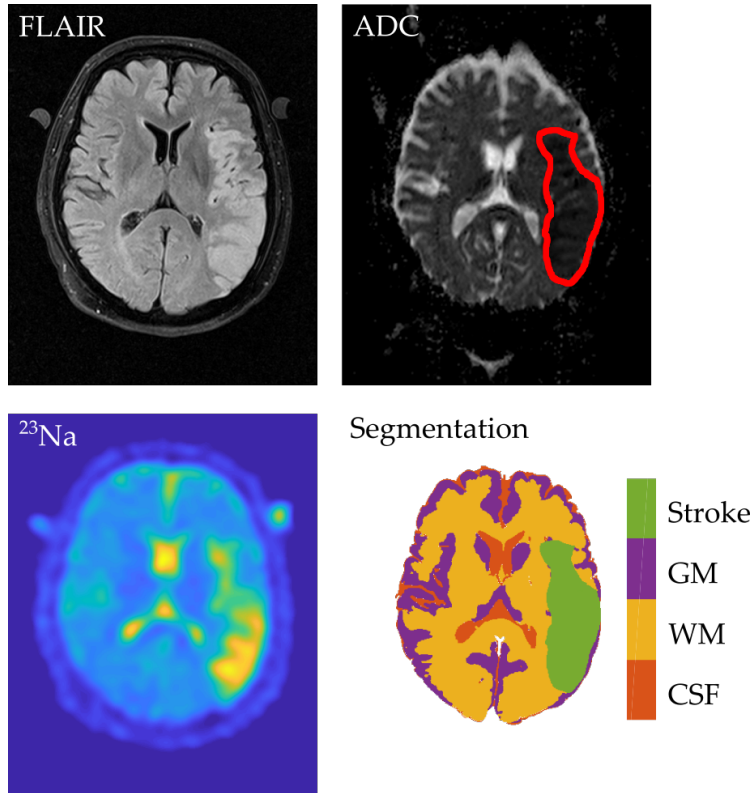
An exemplary transverse image slice of a  $^1\text{H}$  FLAIR MR image (top left), the co-registered ADC-map (top right), and the co-registered  $^{23}\text{Na}$  MR image (bottom left) of one patient with ischemic stroke with the corresponding segmentation map into CSF, WM, GM and the stroke region (bottom right). Co-registration and segmentation into CSF, WM, and GM was performed with SPM12. Segmentation of the stroke region was achieved through manual segmentation based on the co-registered ADC-map, as is depicted with the red line. The manual segmentation was performed by a neuroradiologist.
